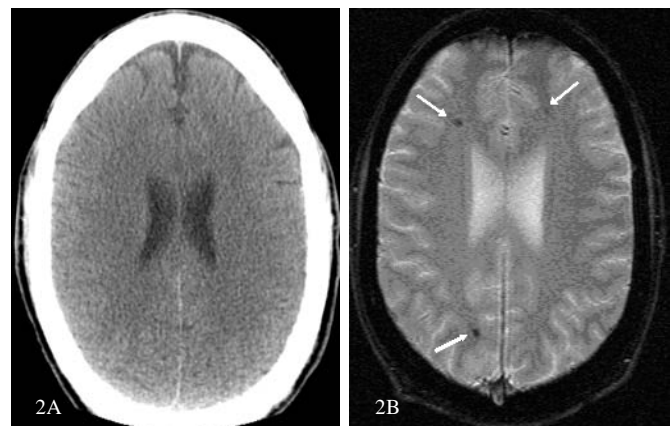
Non-contrast CT (A) on our second case fails to demonstrate abnormality. Axial GRE (gradient echo, B) image at the corresponding region shows multiple low signal foci, two in the right hemisphere and a less conspicuous focus in the left frontal lobe consistent with hemosiderin deposition (arrows).
